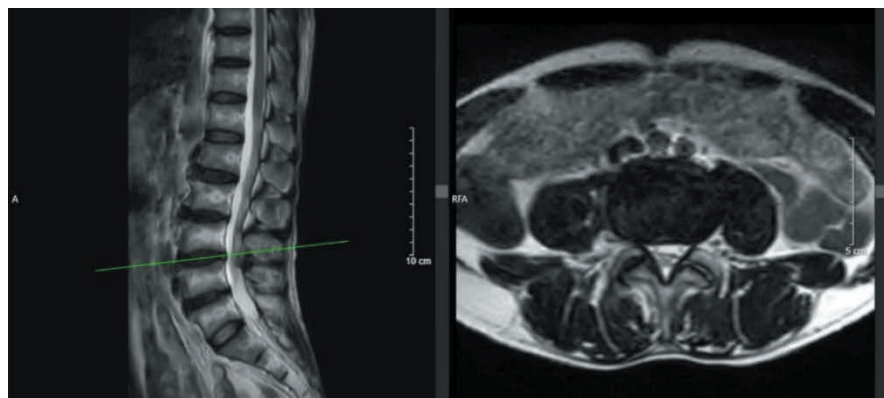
MRI images of the lumbar spine more than 2 months after intervention: no L3/4 disc herniation was observed.
